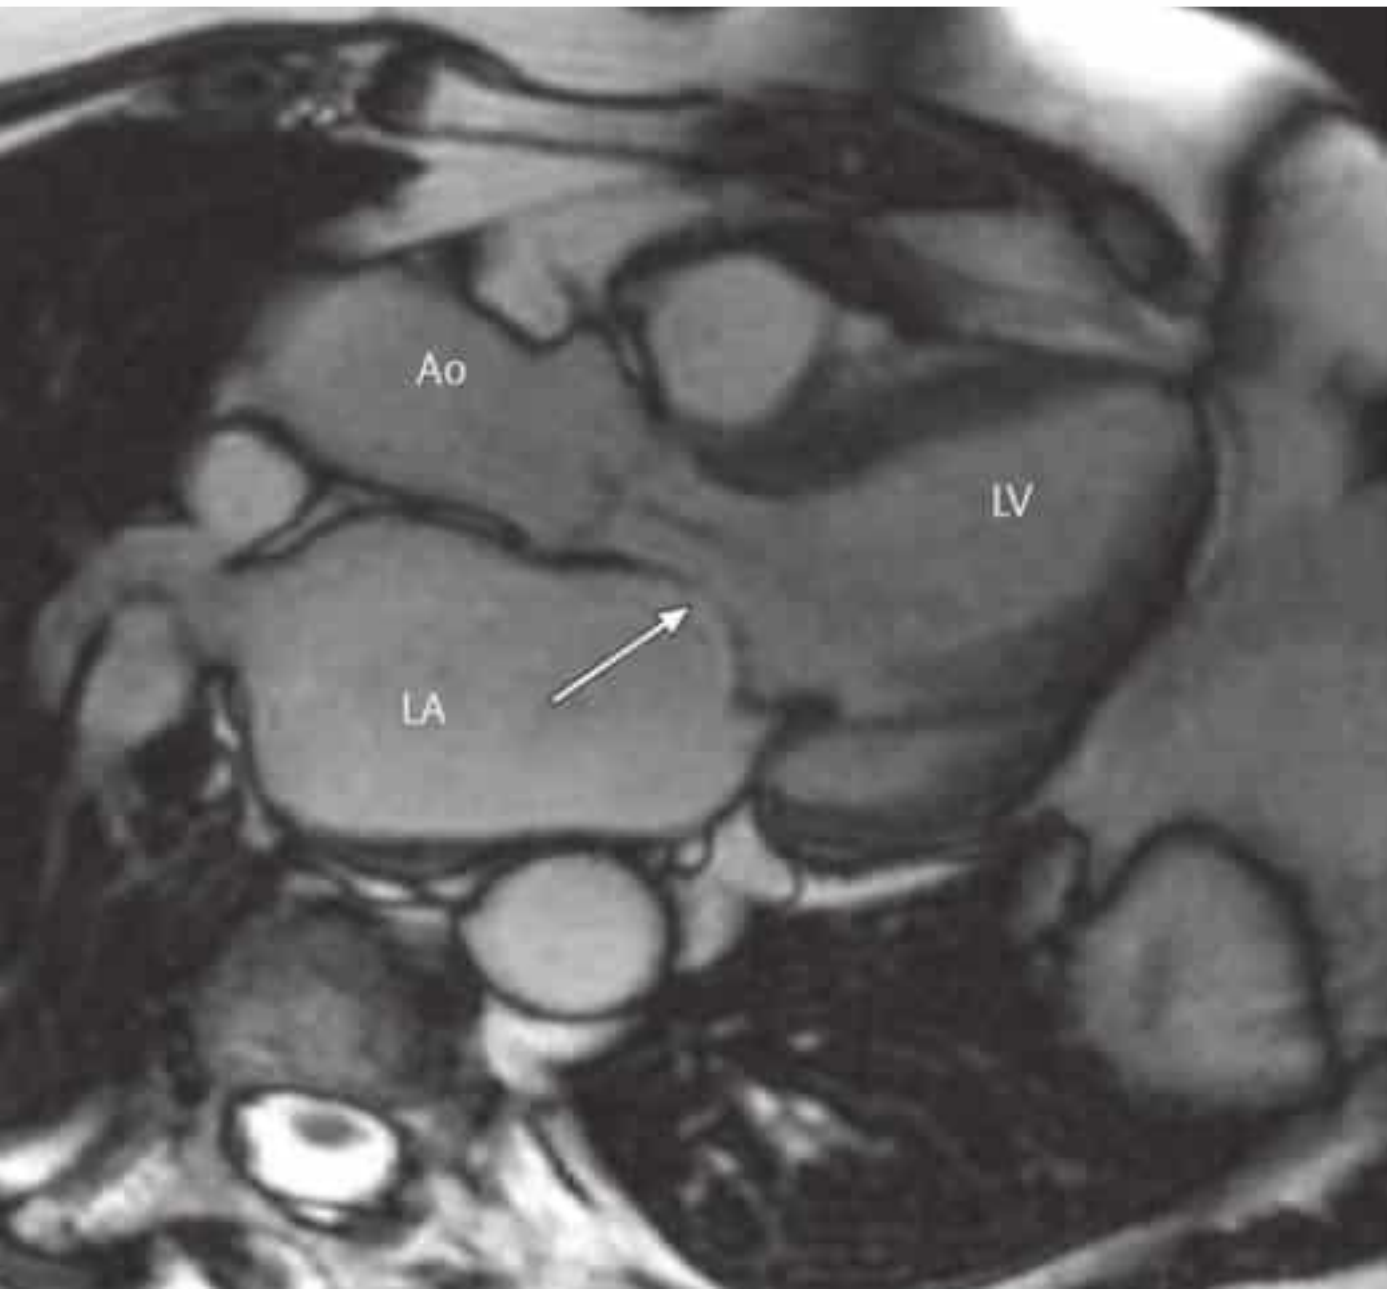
MRI of mitral stenosis and aortic insufficiency in a 68-year-old man. Diastolic image shows both a jet phenomenon below the aortic valve and an abnormally small mitral valve orifice with doming of the anterior mitral leaflet (arrow).
